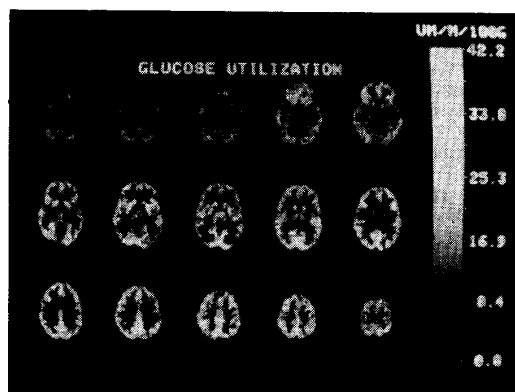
15-slice FDG dataset collected on the PC-2048 with wobble and reconstructed with a 6 mm FWHM resolution filter. Data were collected for 900 s, 45 min after a 5 mCi injection of FDG. Slices 7 and 8 contain 0.94M and true 1.27M counts.
